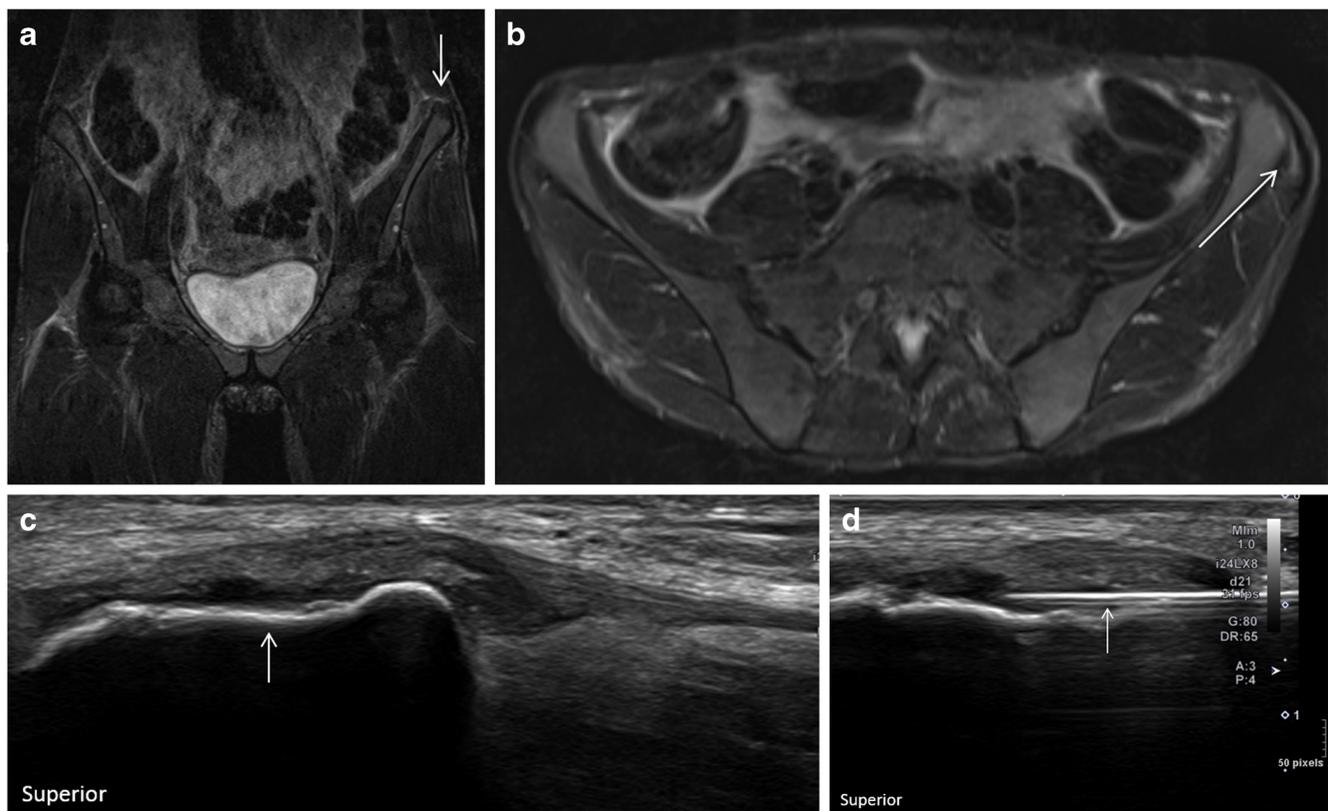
A 27-year-old female competitive marathon runner with left hip pain for several months. Physical exam demonstrated mild tenderness to palpation over the anterior left iliac crest. MRI was initially obtained. a Coronal and b axial STIR MR images demonstrate scarring and partial-thickness tear of the left FLAIC (*arrow*). c Longitudinal high-resolution
